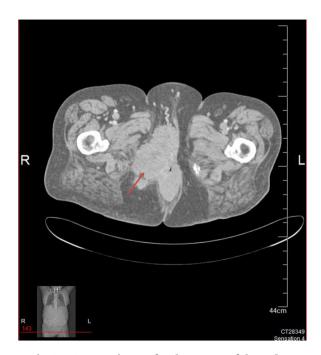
CT scan image for the tumor of the vulva.
